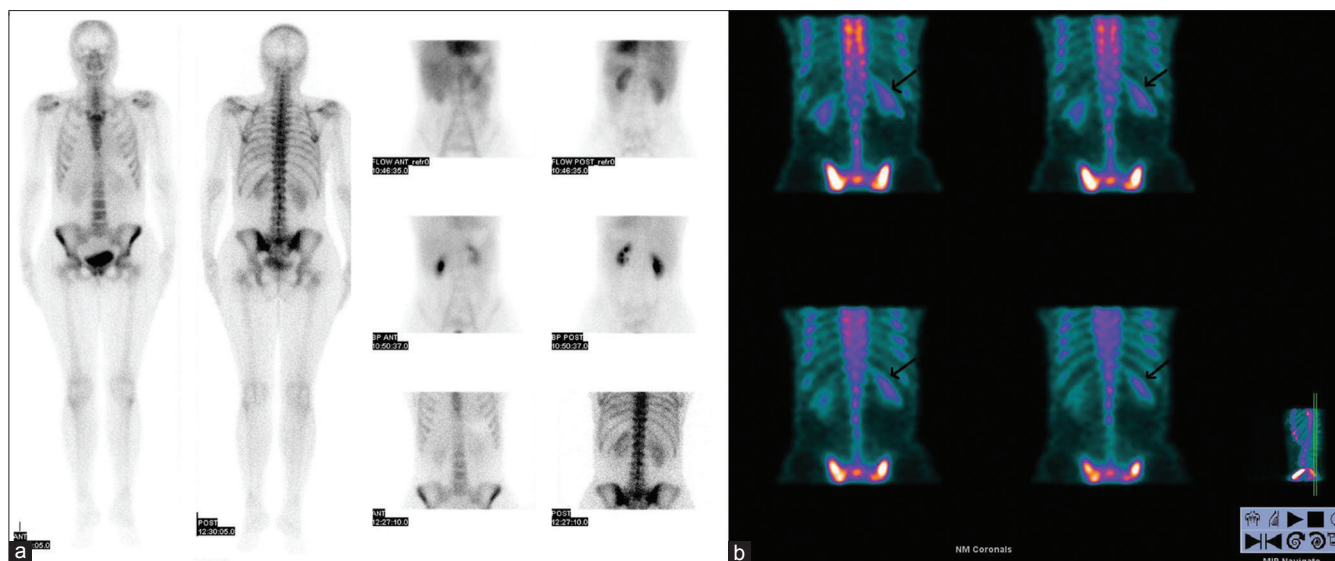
(a) There were not seen the ribs of 12th and moderate diffuse activity involvement was observed on the left 11th rib on the whole body bone scintigraphy (b) There was diffuse increased uptake in the left 11th rib (arrow) on the coronal single-photon emission computed tomography images
